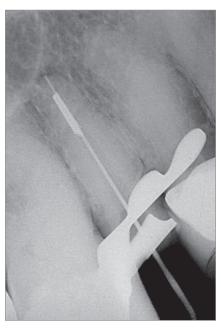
Radiograph showing the file reaching beyond the silver cone.
